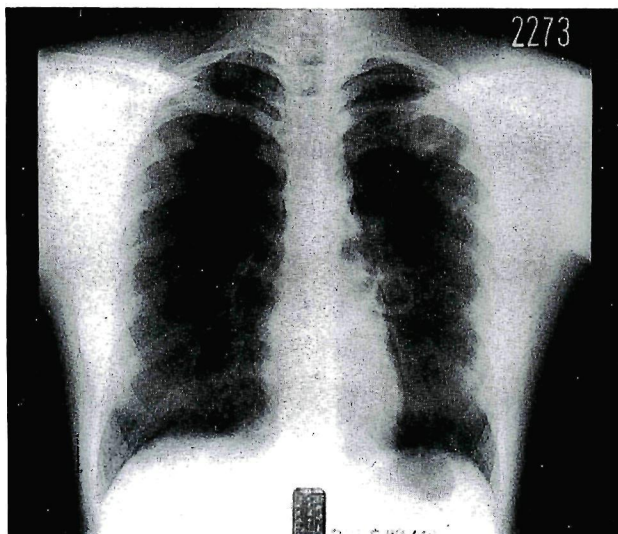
Chest x-ray of Case B (bII2).
